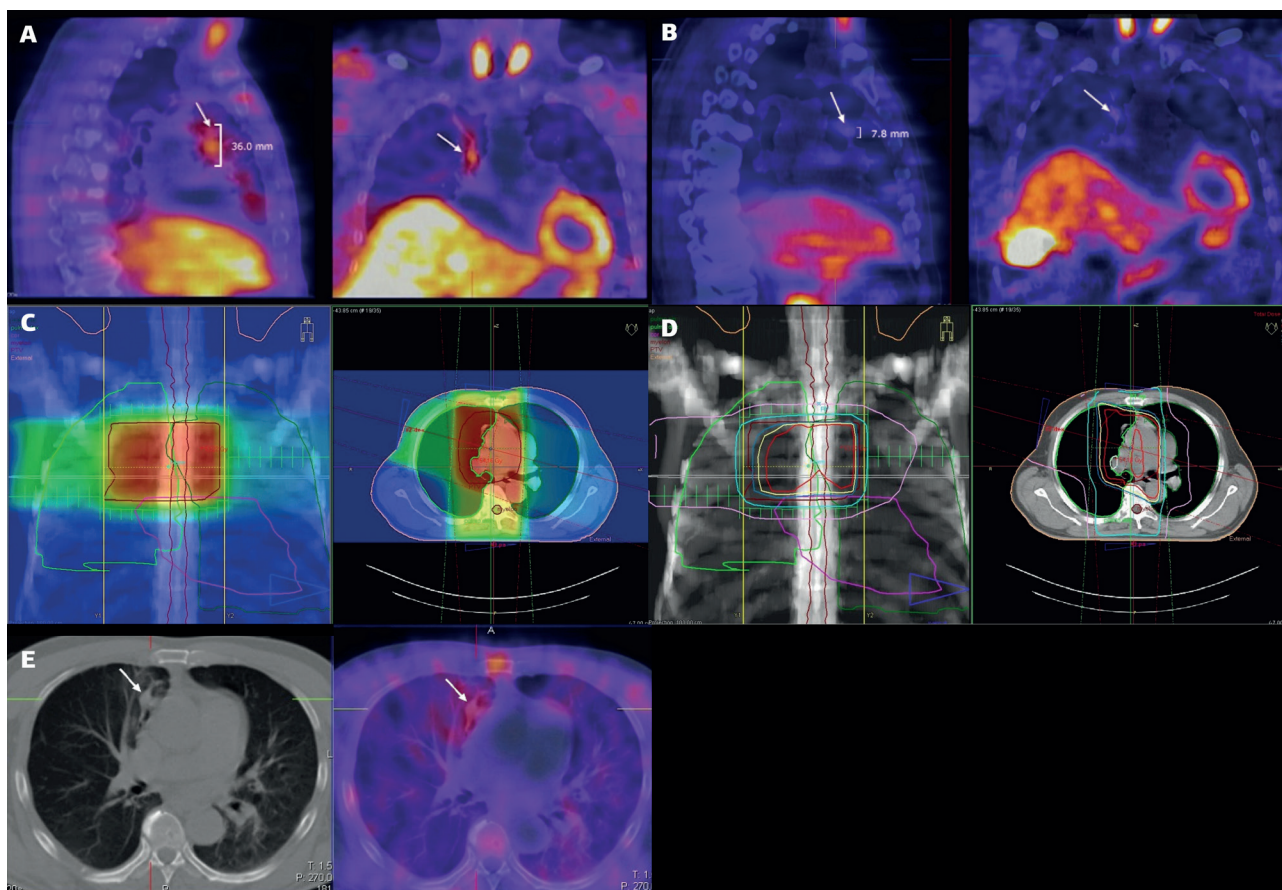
A: A patient with thymoma and infiltration of the right lung after surgery. SPECT-CT ^{99m}Tc -MIBI showed residual tumor mass with intensive tracer uptake in the region of the right mediastinal pleura and anterior mediastinum with sagittal size of 36 mm (arrow). B: Control study after EBRT showed reduced size (7.8 mm) (arrow) with decreased tracer uptake. C: Dose plan - coronal and transaxial CT images. D: Coronal and transaxial images showing the PTV (red line) and dose distribution. E: Diagnostic SPECT-CT can change treatment volumes by identifying involved mediastinal pleura (arrow) and mediastinal lymph nodes. Contrast-enhanced CT showing a right paratracheal node 10 mm in short axis diameter (arrow). The corresponding slice on SPECT-CT shows intensive uptake. This node should be contoured as CPTV. CT scans are obtained from the cricoid cartilage to the superior aspect of the L2 vertebra to allow the lung DVH to be calculated. A co-registered SPECT scan can be used to aid volume definition. Defining volumes on a SPECT-CT image may help distinguish residual tumor and lymph nodes from other structures.
